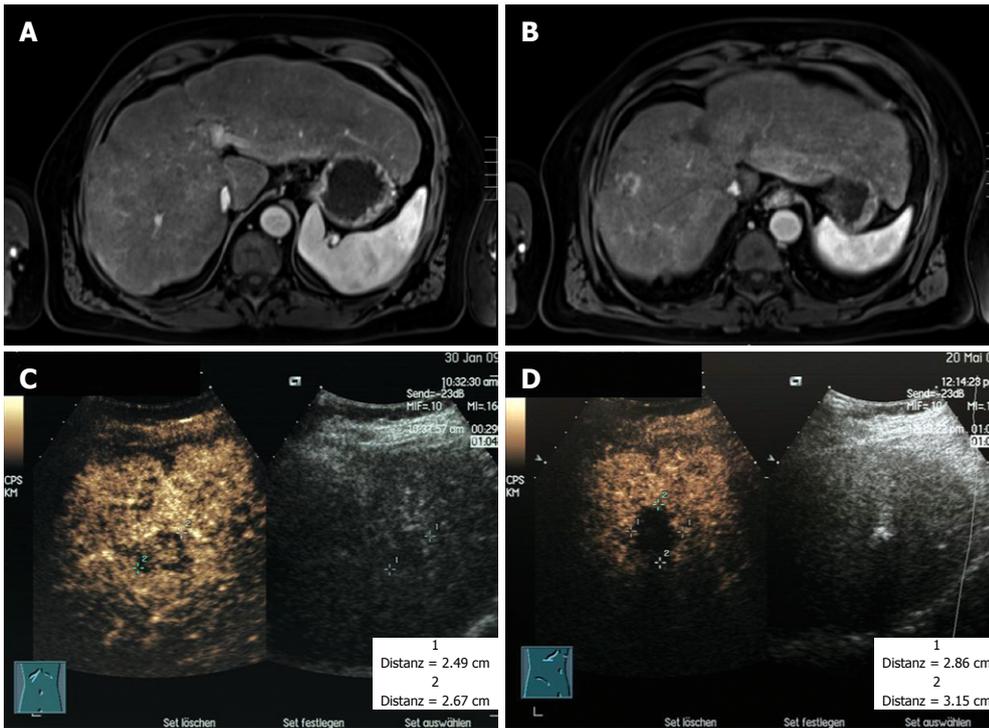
Magnetic resonance imaging scans of the liver in spring 2009, 18 mo after initiation of sorafenib therapy (A, B) and the contrast-enhanced ultrasound investigation of a single calcifying lesion of segment IVa before (C) and after (D) ablation by ultrasound controlled high frequency thermotherapy in spring 2009.
